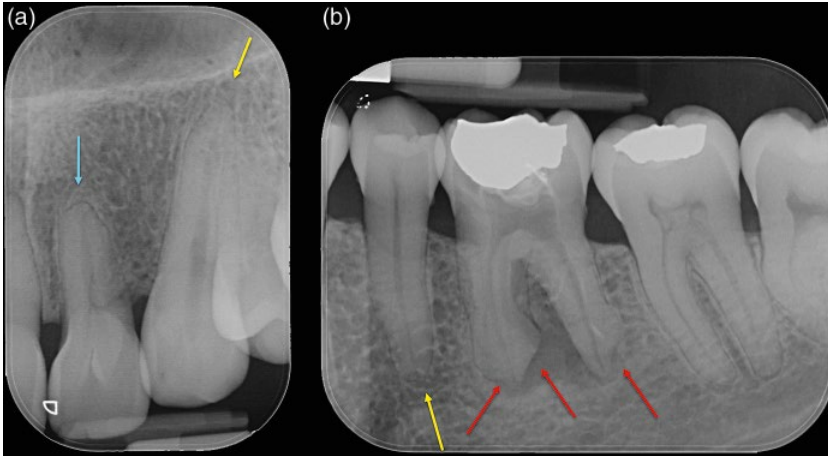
Normal apical periodontium. (a) Shortening of the root and blunting of the root end (blue arrow) of tooth 22 following resorption caused orthodontic fixed appliance therapy. The root end of the adjacent tooth 23 (yellow arrow) has a well-rounded, well-defined radiographic appearance typical of a root apex unaffected by disease processes or pressure related resorption. (b) External inflammatory resorption on the apices of the roots of tooth 36 due to an infected necrotic root canal system and apical periodontitis of the tooth. The root apices of tooth 36 have become flattened and uneven in comparison to the root end of tooth 35 (yellow arrow), which is unaffected by apical periodontitis.
